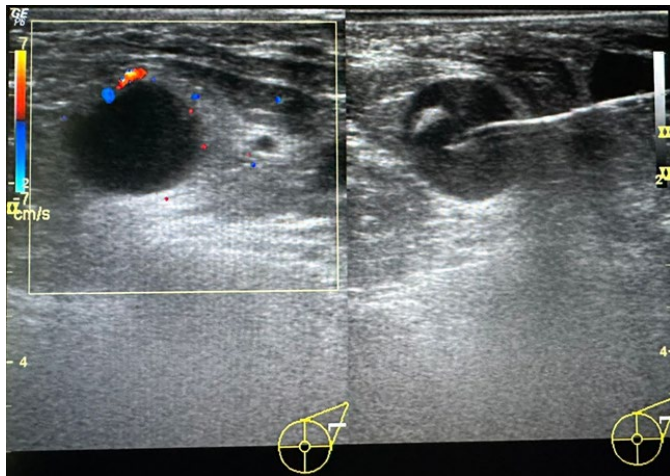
This is Ultrasound Image of Left Axilla Showing a Rounded Hypoechoic Axillary Lymph Nodes with Loss of Fatty Hila. Color Doppler Imaging (CDI) Exhibits Peripheral Vascularity, Suggestive of a Metastatic Lymph Node.
